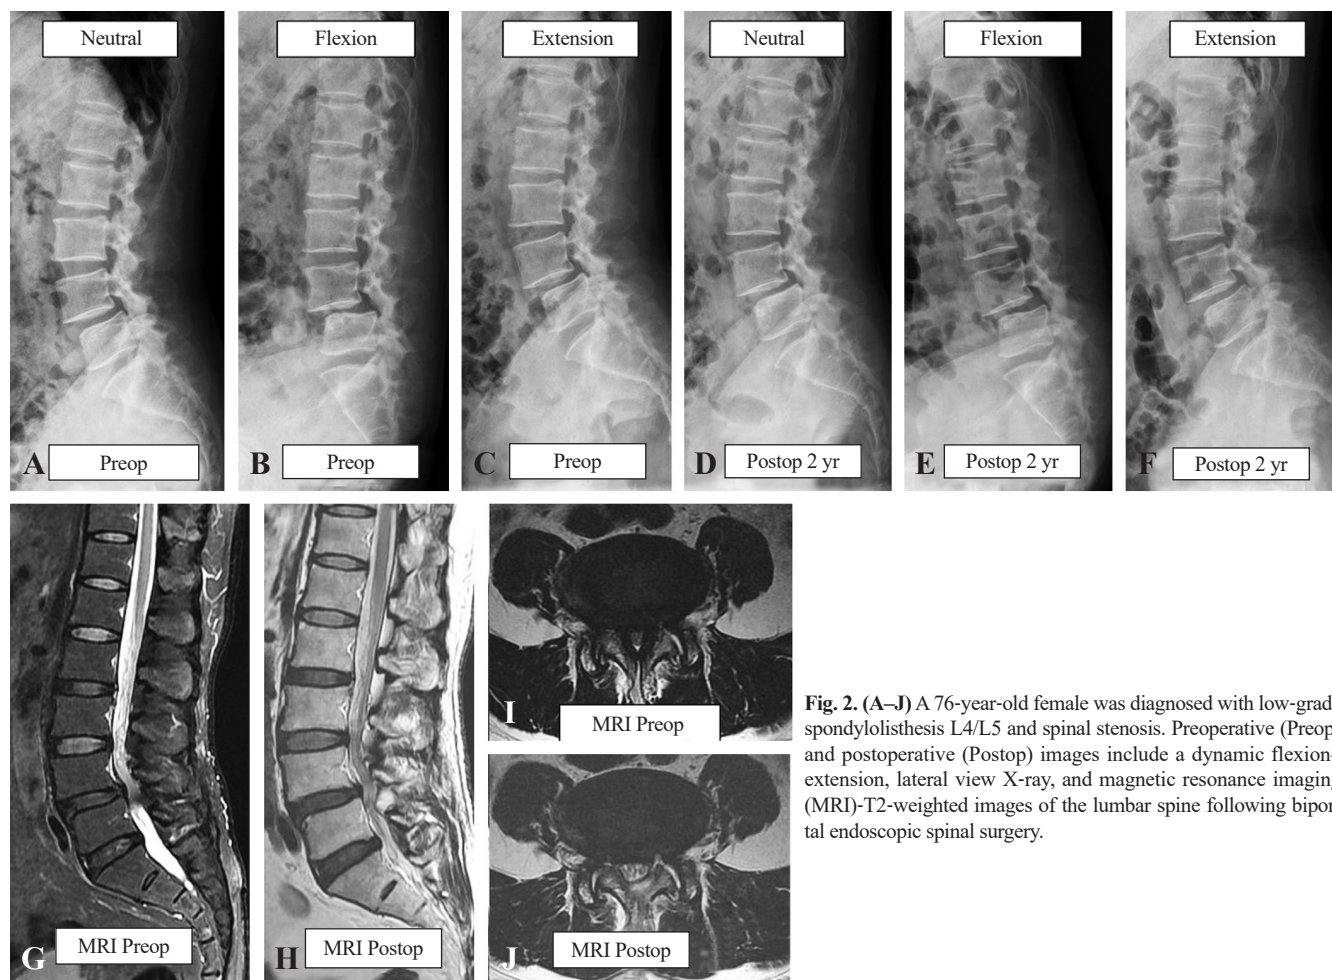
(A–J) A 76-year-old female was diagnosed with low-grade spondylolisthesis L4/L5 and spinal stenosis. Preoperative (Preop) and postoperative (Postop) images include a dynamic flexion–extension, lateral view X-ray, and magnetic resonance imaging (MRI)-T2-weighted images of the lumbar spine following biportal endoscopic spinal surgery.
